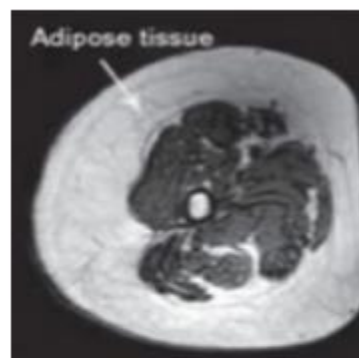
MRI Cross sections of thighs at different ages and states of health
